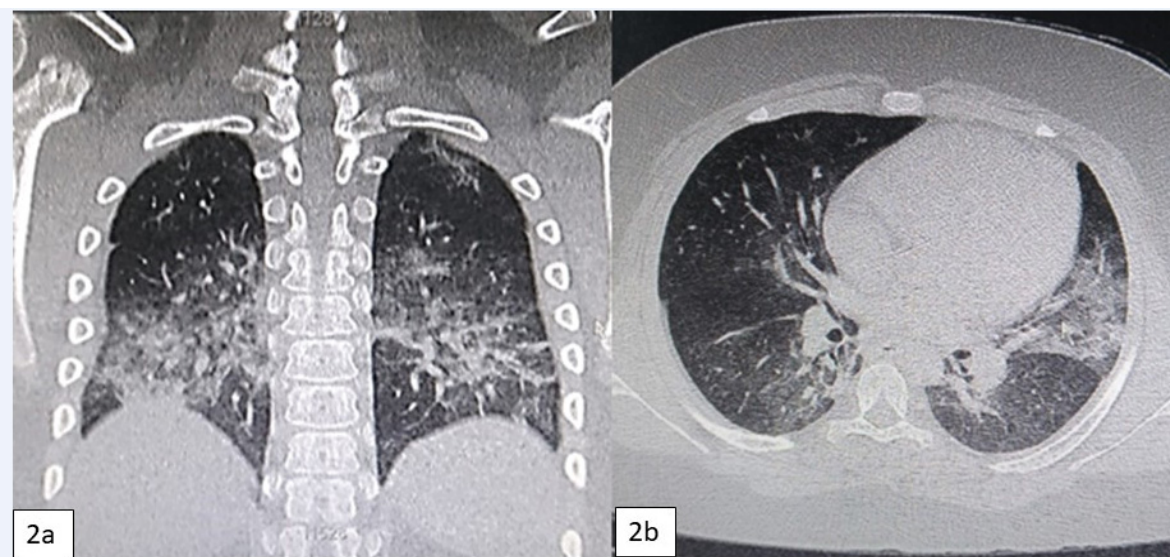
(a) CT coronal view. (b) CT axial view.
